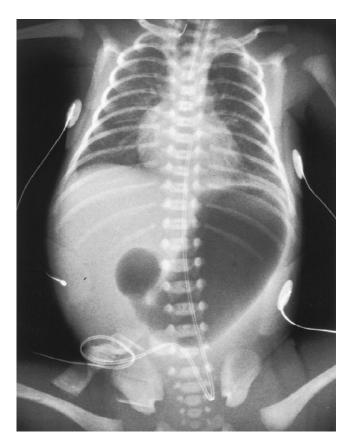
Plain radiograph of a newborn, showing dilated stomach and proximal duodenum with lack of air distal to the obstruction.
